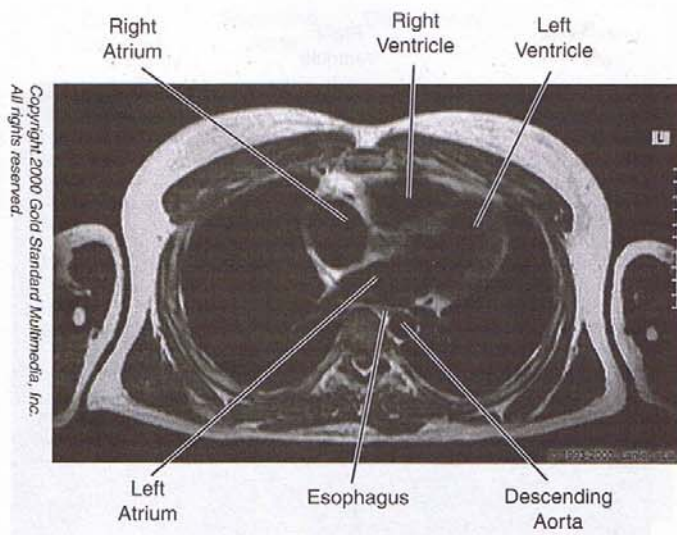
Chest: MRI, Axial T₆
